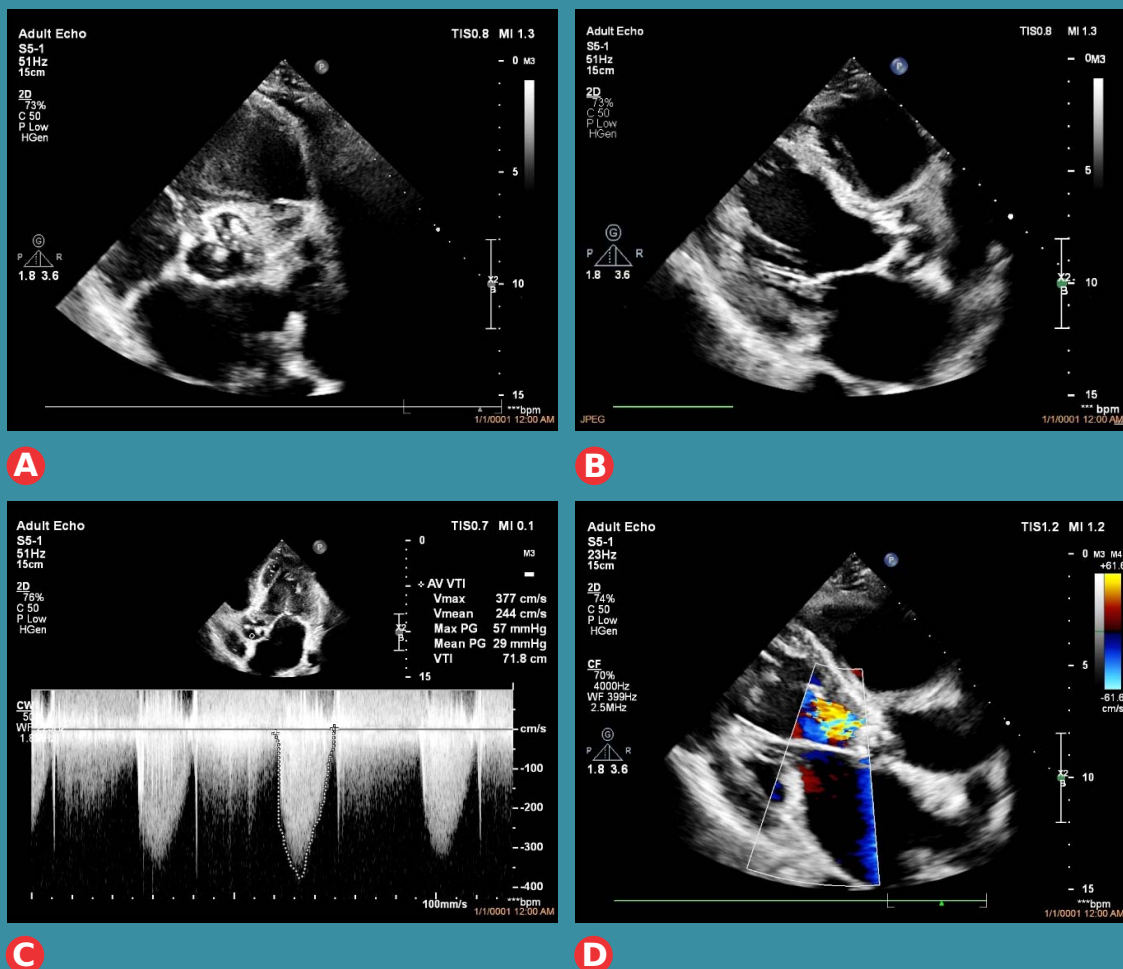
Echocardiographic findings: a) bicuspid aortic valve and multiple hyper-echoic masses, b) two of hyper-echoic masses measuring 8 x 0.4 mm and 11 x 0.5 mm, c) moderate aortic stenosis, d) severe aortic regurgitation in Color Doppler.
